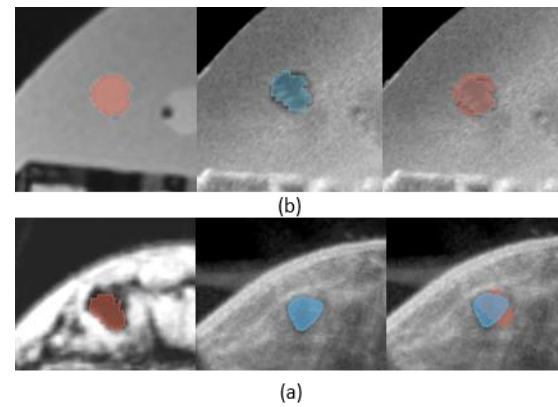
Result of the MRI – 3D US image registration evaluated with cyst as an internal marker in (a) volunteer and (b) the QBP. From left to right: segmented cyst in MRI, segmented cyst in 3D US, and fused segmentations visualized in 3D US.
